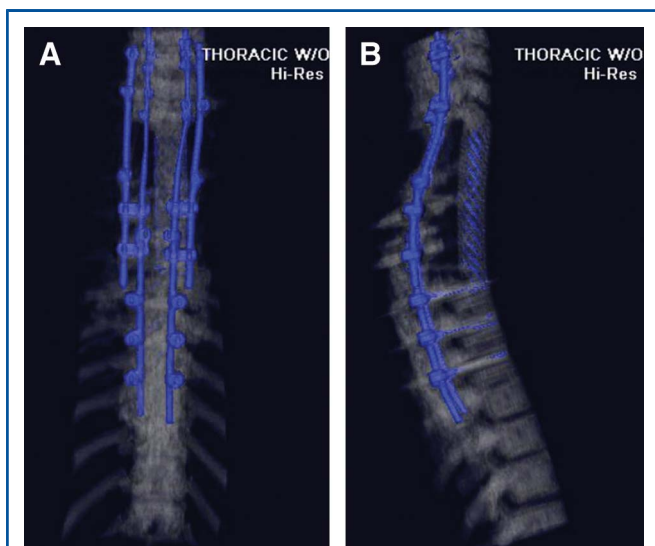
Three-dimensional computed tomography reconstructions of final construct from an anteroposterior view (A) and lateral view (B).
